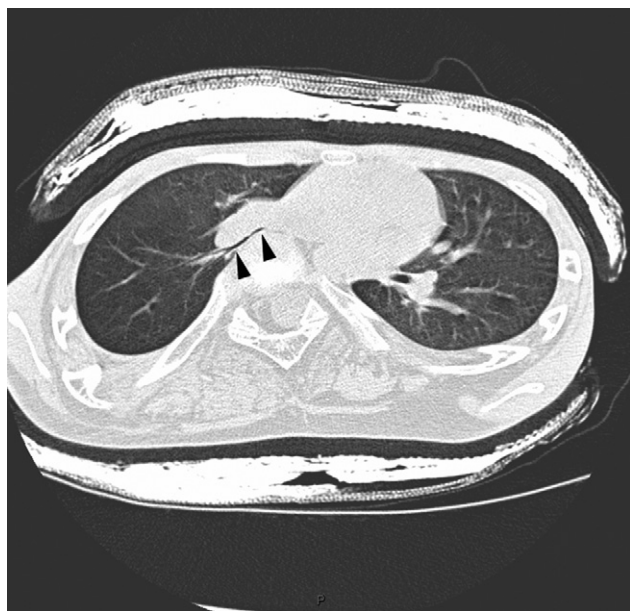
CT slice confirming right middle lobe bronchus stretching (arrows) in contact with vertebral body in girl with evolutive scoliosis with thoracic lordosis.
